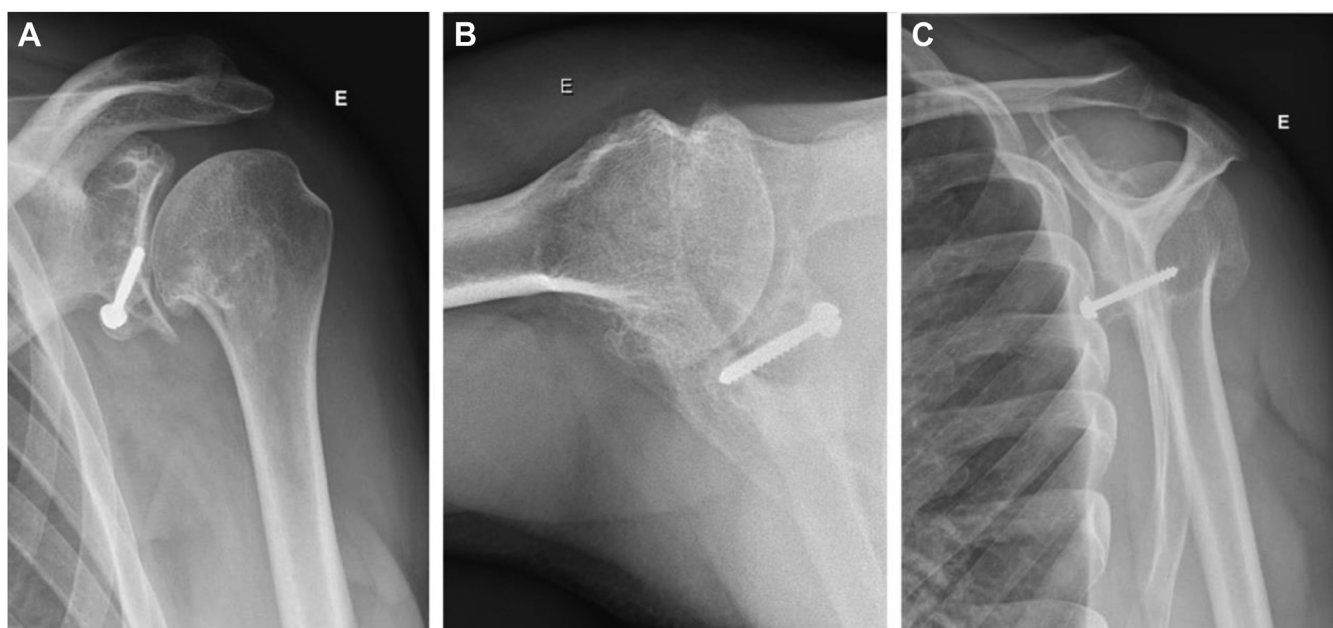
Radiography with moderate glenohumeral arthropathy (3–7 mm).
